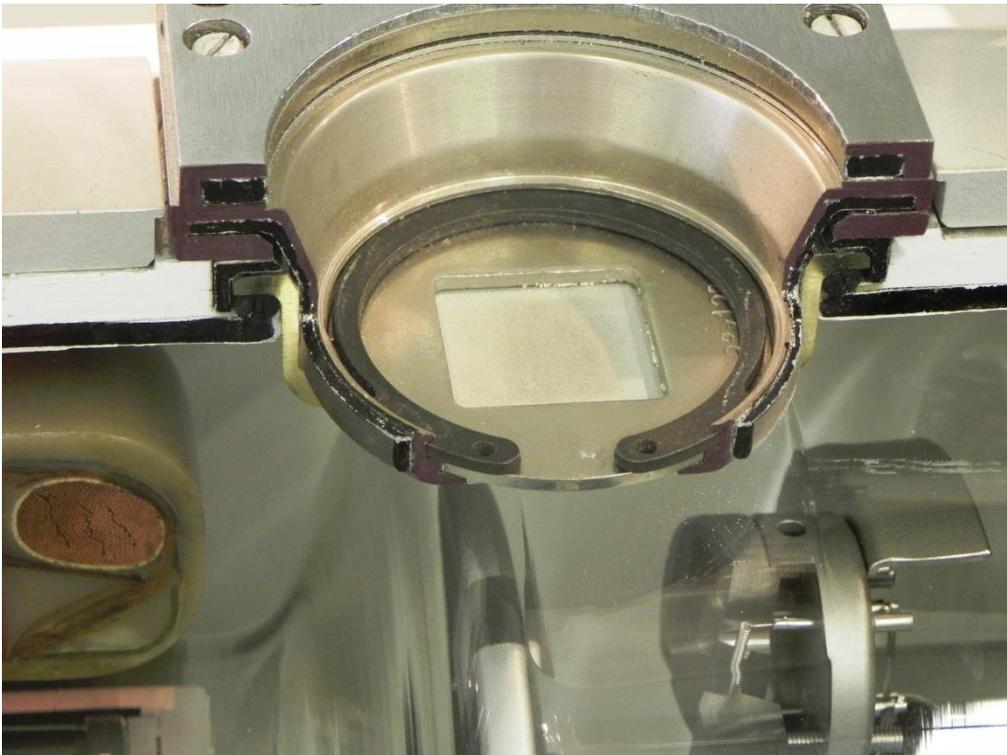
Close-up view of the radiation port of a Philips tube housing assembly for radiography and angiography with exchangeable near focal spot aperture against off-focal radiation and intrinsic radiation filter.
